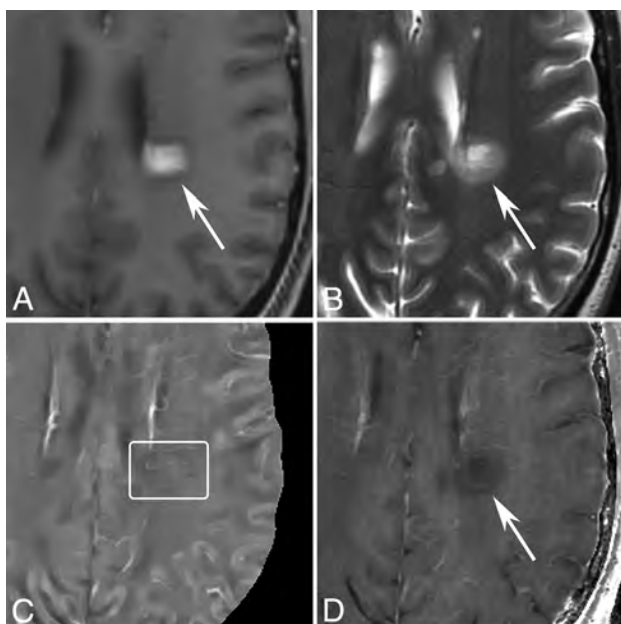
MR images of a nodular-enhancing lesion in a 43-year-old man with MS. A, T1WI + Gd. B, T2WI. C, QSM. D, R2*. A nodular-enhancing lesion (arrows) is found on the T1WI + Gd and appears QSM isointense (C, box).
